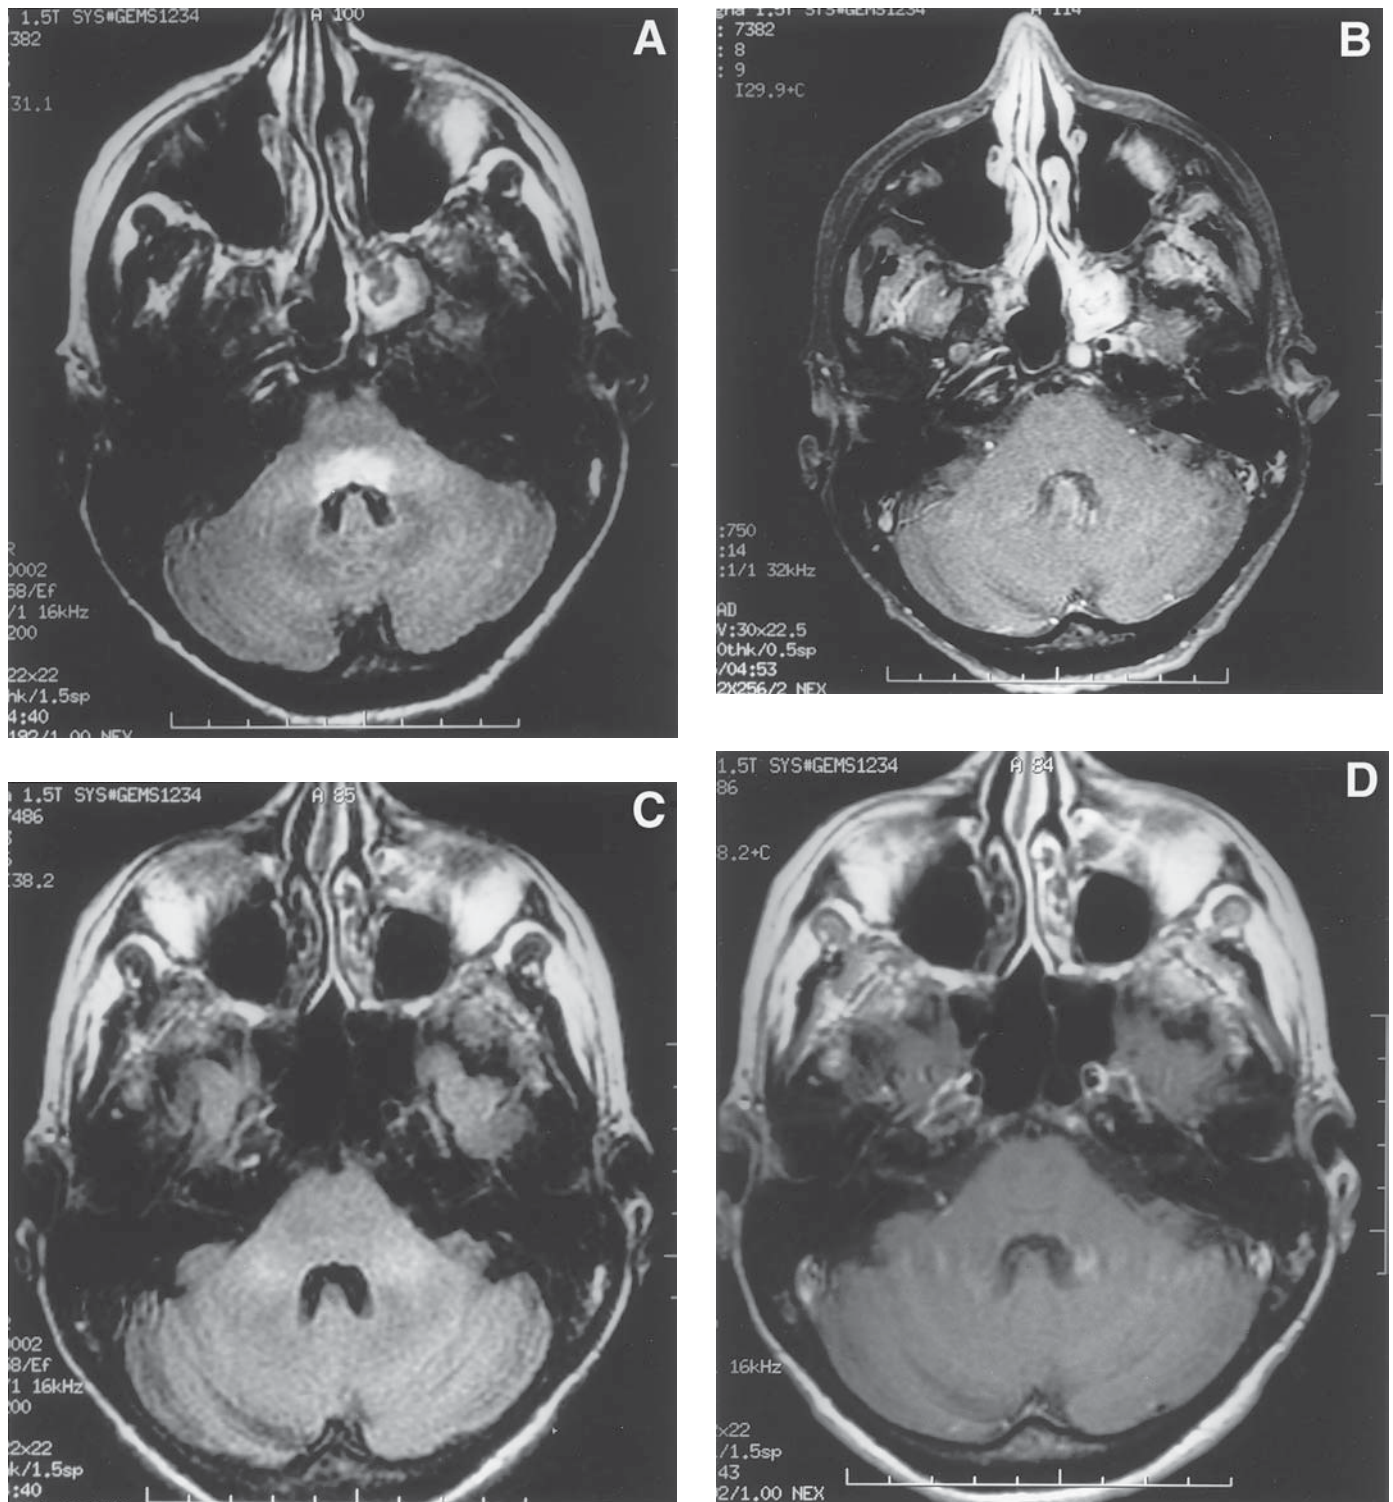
Axial MRI scan (FLAIR images, A) of a 48 yr old female 9 mo after match-related T-cell depleted bone marrow transplant for CLL (T1-weighted with gadolinium, B). An episode of headaches, fever, nausea, and vomiting preceded mental status changes, somnolence, and coma. Hyperintense lesions in the tegmentum pontis and dorsal portion of medulla oblongata were noted at that time. All metabolic and infectious studies in serum and CSF were unremarkable. Tonic-clonic seizures developed and were treated with phenytoin. Spontaneous clinical and radiographic recovery were seen after 1 wk (C and D).
